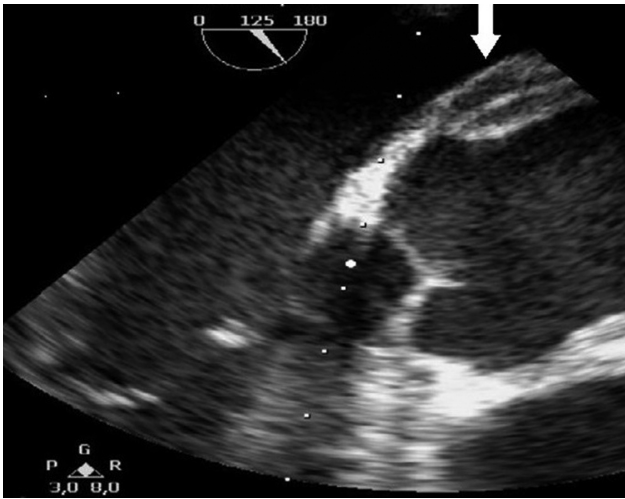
Preoperative transesophageal echocardiography demonstrating a paraaortic effusion (arrow) believed to be a paraaortic abscess formation.
